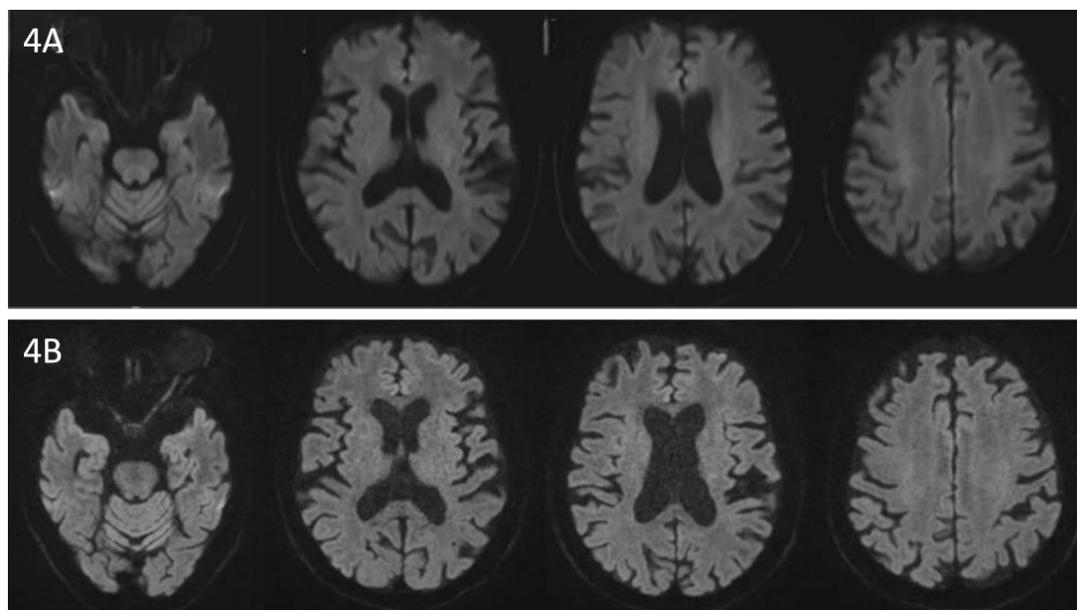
Persistent diffusion-weighted imaging (DWI) negativity despite progressive cerebral atrophy. (A) Baseline DWI (2023) showing no restricted diffusion or abnormal hyperintensity. (B) Follow-up DWI (2024) confirming continued absence of pathological signals, while concomitant structural sequences reveal advancing sulcal widening.
